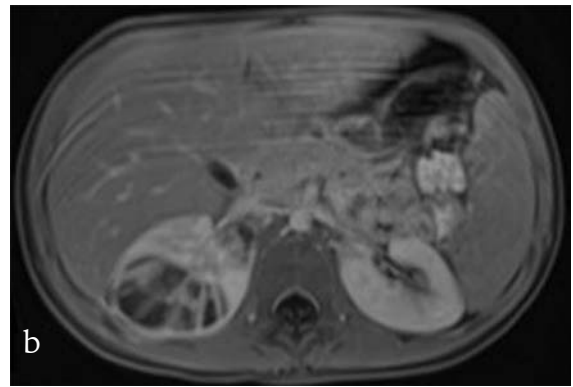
Axial MR images of the right kidney, revealing the ALN lesion involving the upper pole. On the T2-w image (a), it has both hypo- (arrow) and hyperintense (arrowheads) components, but no capsule. The T1-w image (b) shows the extension of ALN into the lobules without any enhancement. Note that on the diffusion-weighted image (b=800) (c), the lesion has significant restricted diffusion, while on the ADC map (d), region of interest analysis reveals a reduced mean ADC value ($0.9 \times 10^{-3} \text{ s/mm}^2$) compared to normal renal parenchyma ($2.0 \times 10^{-3} \text{ s/mm}^2$).
